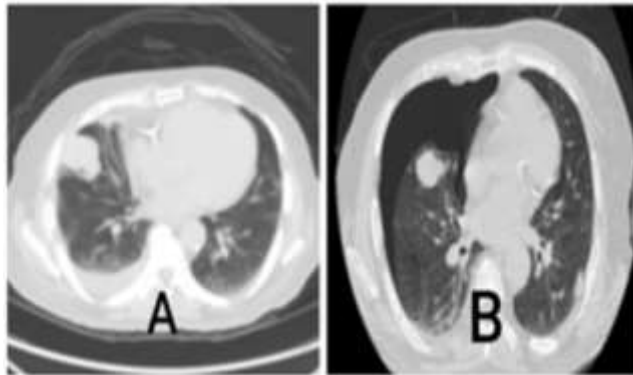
CT-guided chest biopsy of a pulmonary lesion. This demonstrates post procedure perilesional haemorrhage as ground-glass opacity adjacent to the lesion.
